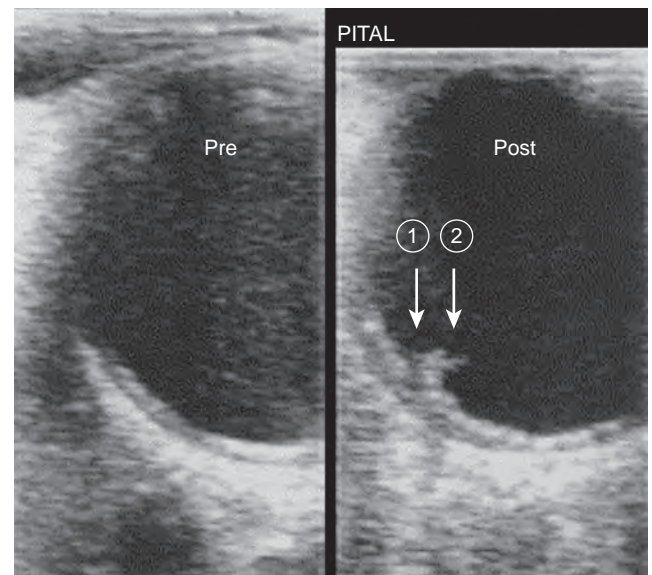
New intimal tear (arrow 1) and new mobile lesions (arrow 2) likely to have been caused by aortic clamping. (From Ura M, Sakata R, Nakayama Y, Goto T. *Ultrasonographic demonstration of manipulation-related aortic injuries after cardiac surgery*. *J Am Coll Cardiol*. 2000;35:1303–1310.)
